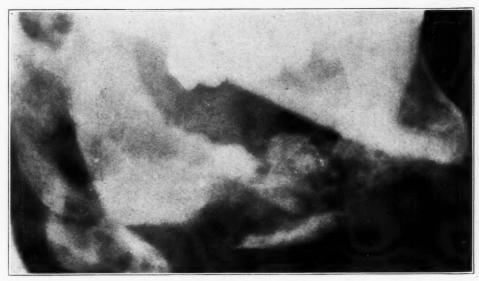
Roentgenogram made March 26, after removal of sequestrum in ramus and removal of segment of inferior border of mandible.
